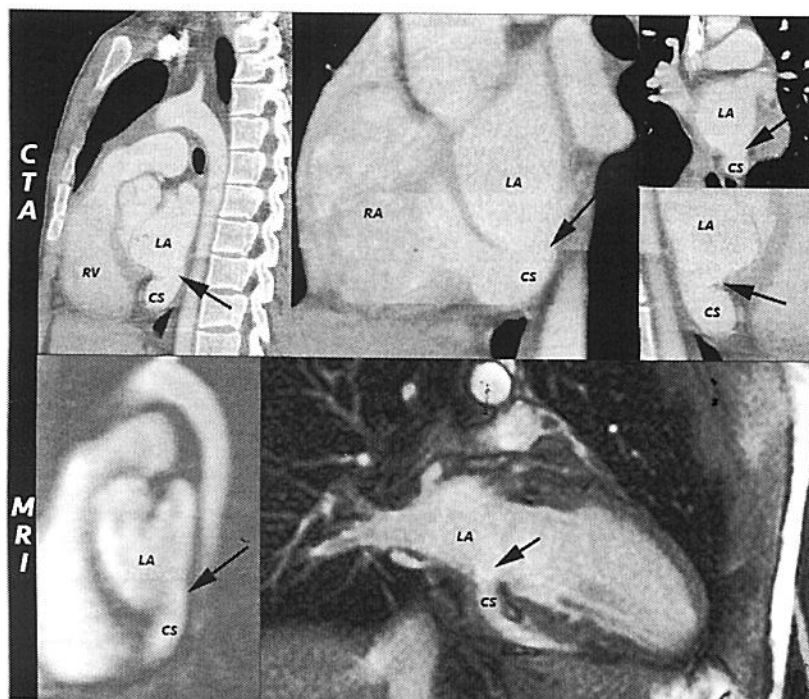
Partial unroofed coronary sinus communicating with left atrium revealed in computed tomography angiography and magnetic resonance imaging. RV = right ventricle, LA = left atrium, CS = coronary sinus, RA = right atrium.
